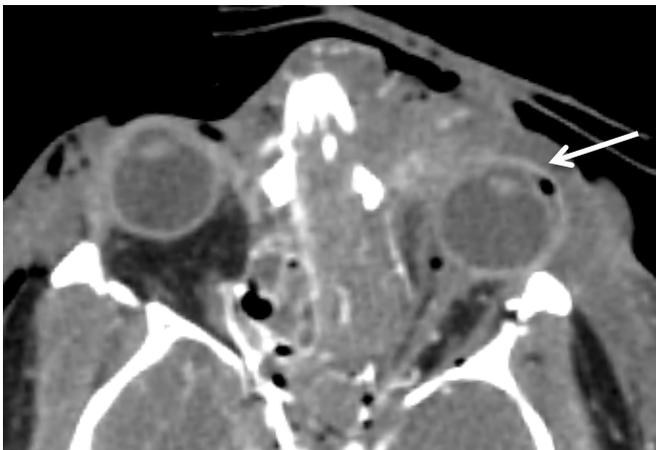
Partially ruptured globe, left eye (49-year-old male). CT, axial section: Ocular globe partially ruptured, apparent by retractions of the bulbar wall with entrapped air (white arrow) and dislocated lens.
